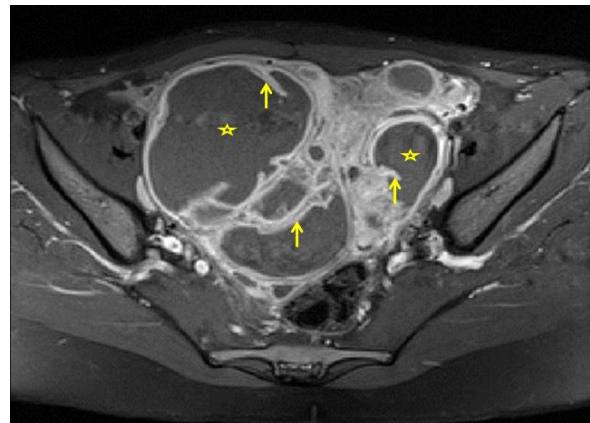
Contrast Enhanced CT scan of the pelvis revealing two multilocular cystic masses (asterisks) with intense enhancement of thick wall, septations (yellow arrows) and peritoneum.
